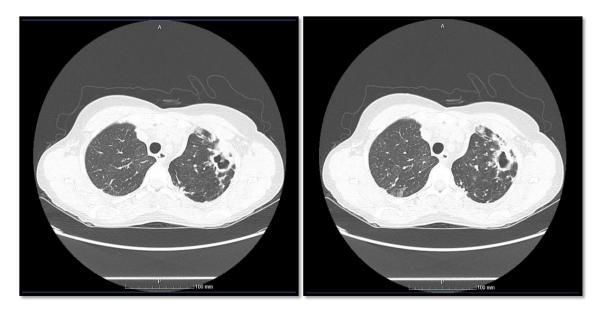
Thoracic computed tomography angiography (27th October 2018) showing a cavitation in the upper left lobe.
